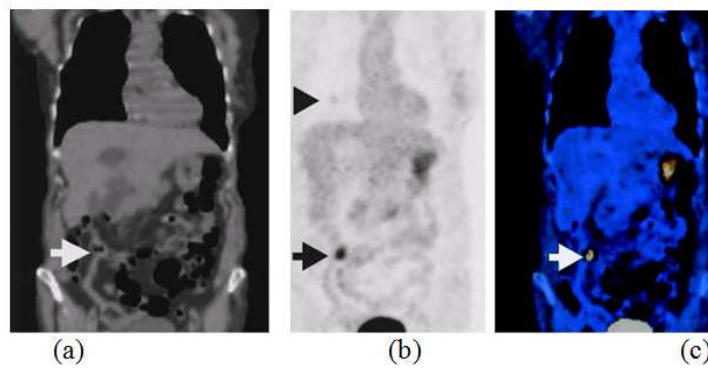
Primary carcinoid tumor of the bowel. CT image (a), PET image (b), and PET-CT image (c)
